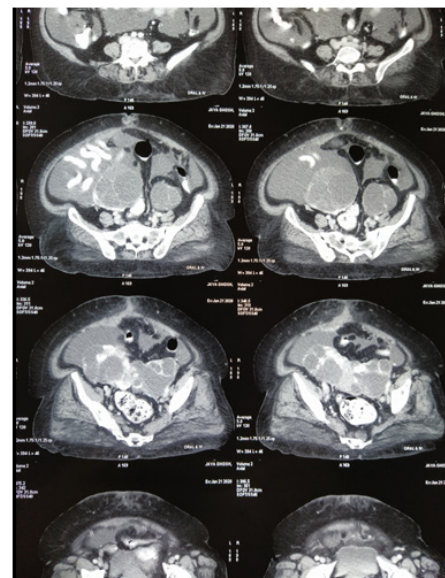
CT scan of SMJN mimics umbilical hernia.
